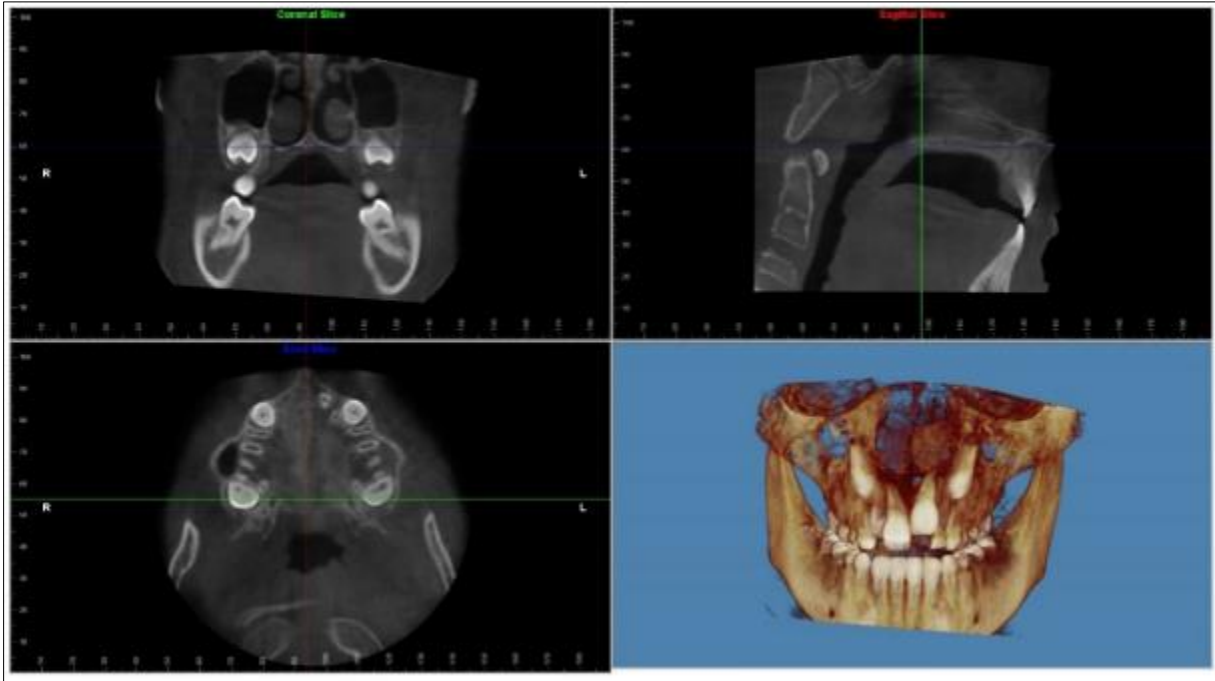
CBCT orientation: position the patient in the axial view such that the coronal plane is aligned with the left and right larger foramen palatine, as well as with the floor of the inferior turbinate. the axial plane's orientation with the palatal plane in the sagittal view and the sagittal plane's orientation with the mid-palate in the axial view.²⁴
